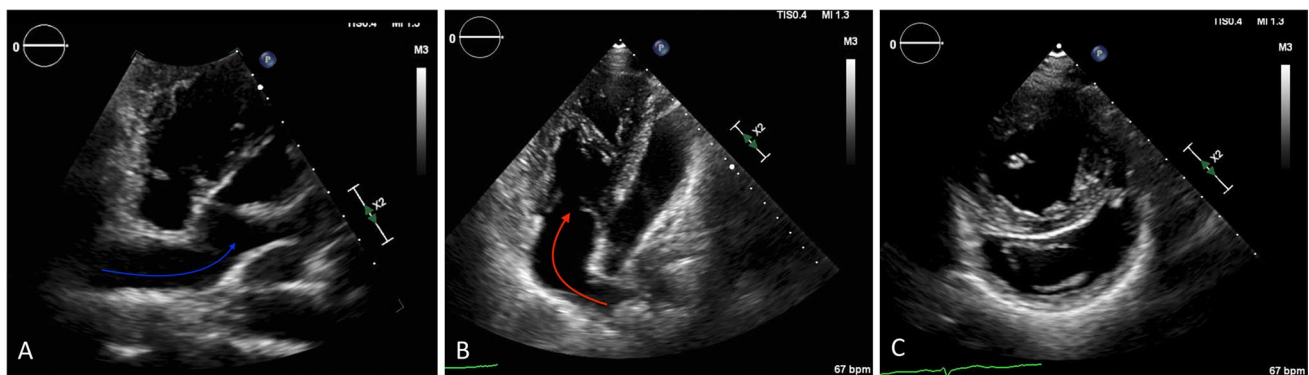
Four-chamber view on a transthoracic echocardiogram shows the intra-atrial baffles seen in a patient with D-loop TGA post atrial switch where baffles are used to restore physiological circulation. A An atrial baffle diverts blood from both vena cava across to the mitral valve and LV (*blue arrow* is in the systemic venous baffle), which ejects blood to the PA. B The oxygenated pulmonary venous blood
